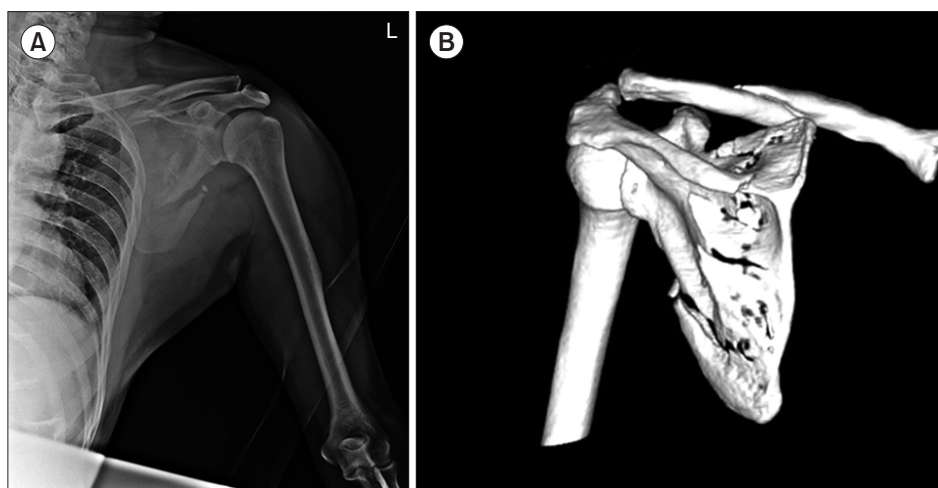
(A) Left shoulder frontal injury radiograph showing a displaced, comminuted, midshaft clavicle fracture and a displaced scapula fracture. (B) Computed tomography 3D reconstruction showing a midshaft clavicle fracture and fractures of the scapular surgical neck and body, consistent with a floating shoulder injury.
